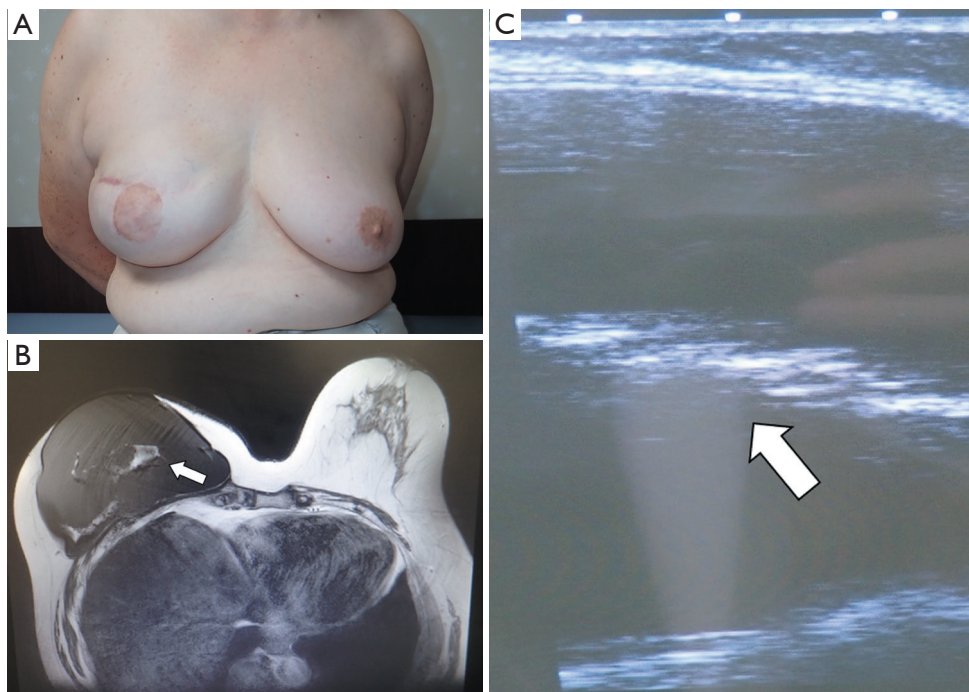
Clinical findings of case 1. (A) Picture of case 1 4-year postoperatively. No abnormal contour findings are observed. (B) Ultrasound finding of case 1. Hyperintense changes are observed inside the implant (arrow). (C) Magnetic resonance imaging findings of case 1. High signal changes inside the implant are observed (arrow).
